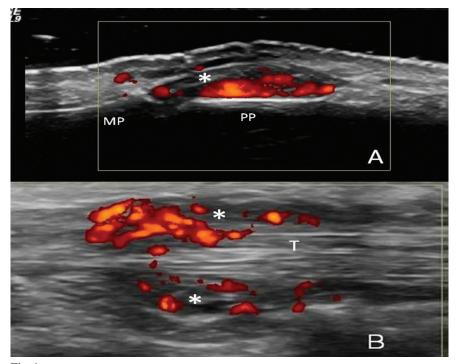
Rheumatoid arthritis. Longitudinal dorsal scan of the proximal interphalangeal joint (A), showing the presence of power Doppler signal in the joint. (B) longitudinal dorsal scan of the IV compartment of the extensor tendons at the wrist. Hyper-perfusion of the synovial tissue is demonstrated. The asterisk indicates synovial proliferation. T = extensor tendon; PP = proximal phalanx; MP = middle phalanx. Images taken using a Logiq 9 (General Electric Medical Systems, Milwaukee, WI) equipped with a 14 MHz linear probe.
